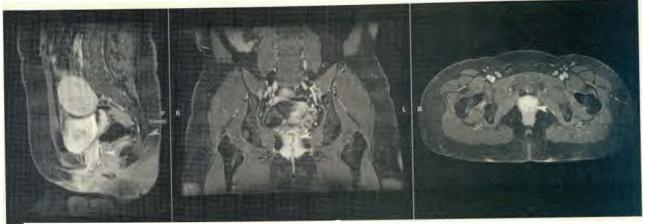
MRI of the pelvis: The vaginal canal measures about 5.0 cm and ends as a blind-ended pouch superiorly at the level of the coccyx. Its patent lower aspect remains distinct from the urethra along their course until the perineum.
